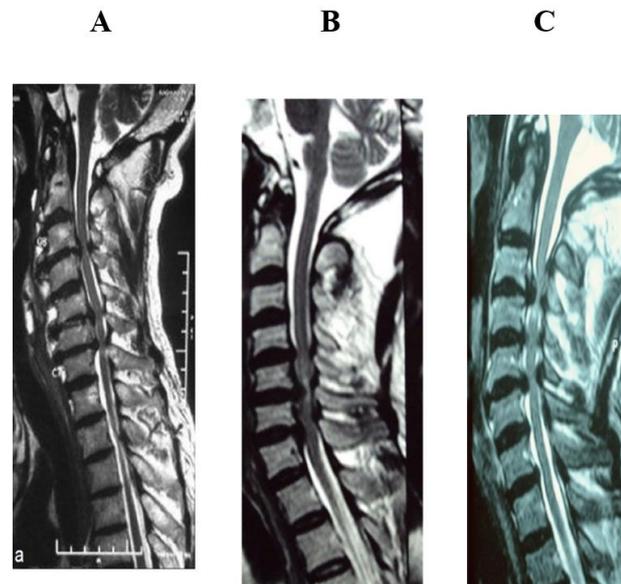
Preoperative sagittal MRI image. A (Cervical 3-4, Cervical 5-6, Cervical 6-7), B (Cervical 4-5, Cervical 5-6, Cervical 6-7), C (Cervical 3-4, Cervical 4-5, Cervical 5-6).
